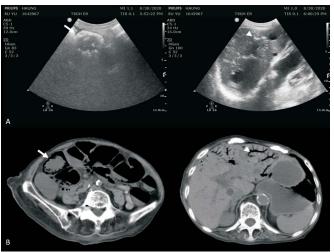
(A) Point-of-care ultrasonography of right lower quadrant showing thin linear intramural air (white arrow) with thickening of the bowel wall and punctate echogenicity within the portal venous branches in the liver parenchyma (white arrowhead). (B) Computed tomography of the abdomen showing segmental continuous small intestine dilatation with pneumatosis intestinalis (white arrow) and gaseous infiltration of the portal venous system and the liver parenchyma (white arrows).
